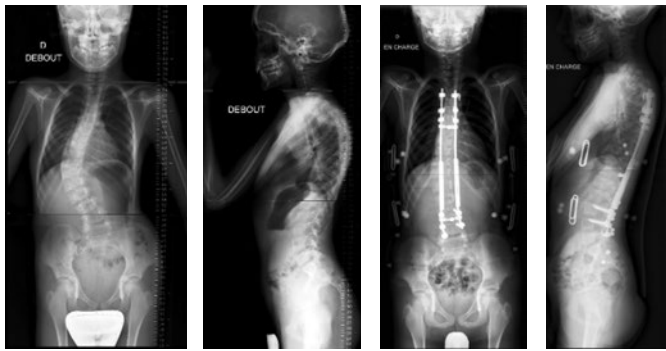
Boy, 10 years old. Progressive thoraco-lumbar scoliosis, despite bracing. AP and lateral Xray (a, b). Bilateral lengthening rods (c, d) : upper T4-T6 hook fixation. Lower L3-L4 screw fixation. Intermediate lengthening rods.
